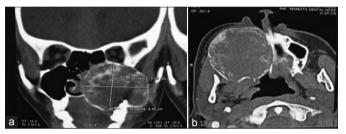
(a)Computed tomography coronal section (well defined mixed radio opaque - radiolucent lesion involved medially medial wall of the nose, superiorly infra orbital rim, laterally posterior wall of the maxillary sinus, inferiorly anterior wall of the maxillary sinus, size of the lesion 4.45 cm × 5.06 cm). (b) Computed tomography axial section (dense radio opaque round mass surrounded by thin, well defined radioopaque rim and complete obliteration of the maxillary sinus).
